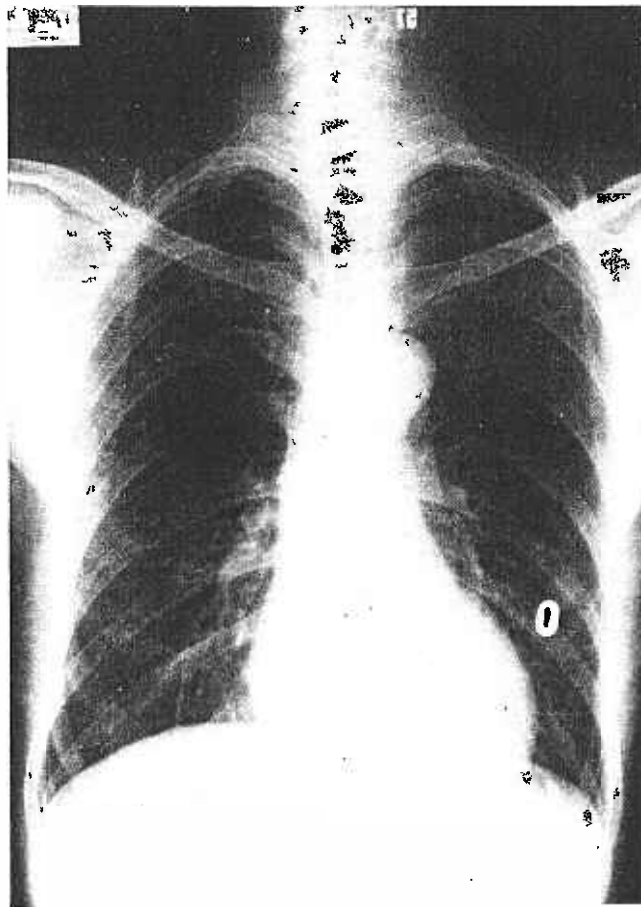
Chest radiograph on 16th February 1979 showing a 1.5 cm opacity in the left lower zone.
